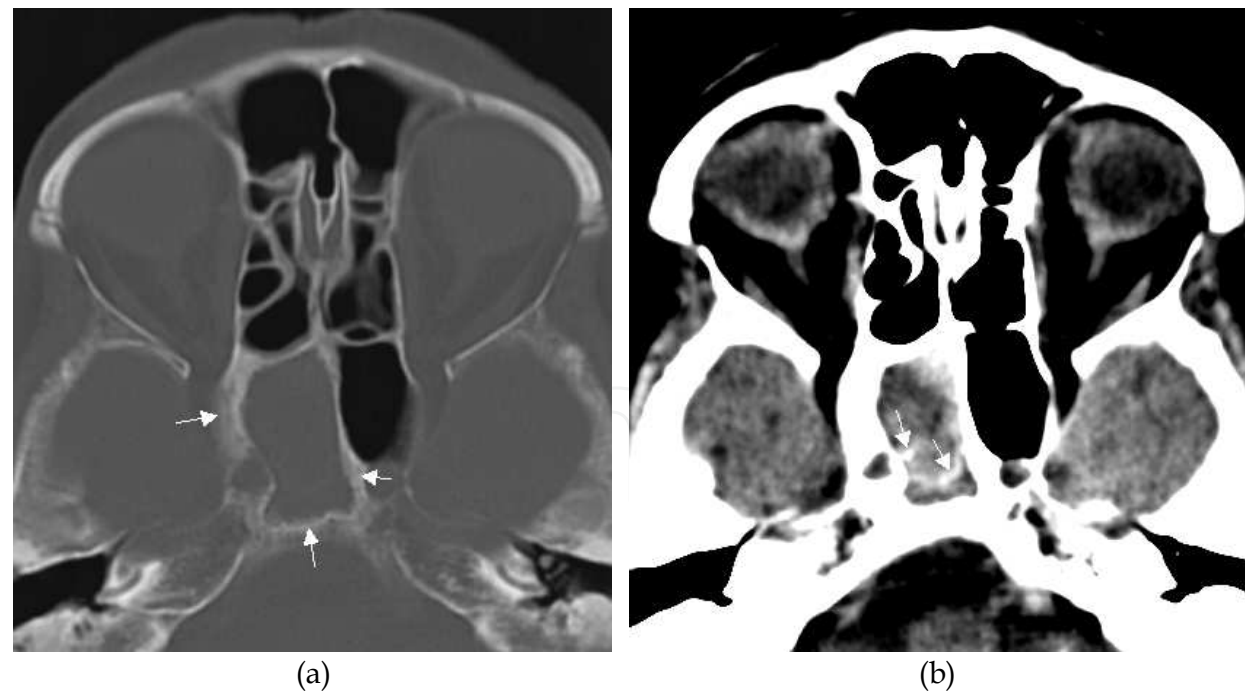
(a) Axial CT with bone algorithm shows total opacification of the right sphenoid sinus. The surrounding sclerotic bone thickening is equivalent to chronic rhinosinusitis (arrows). (b) Axial CT, with soft tissue algorithm reveals hyperdense calcifications (arrows) highly suspicious of a fungal infection. This was an incidental finding in a patient referred to cerebral CT, and missed initially.
